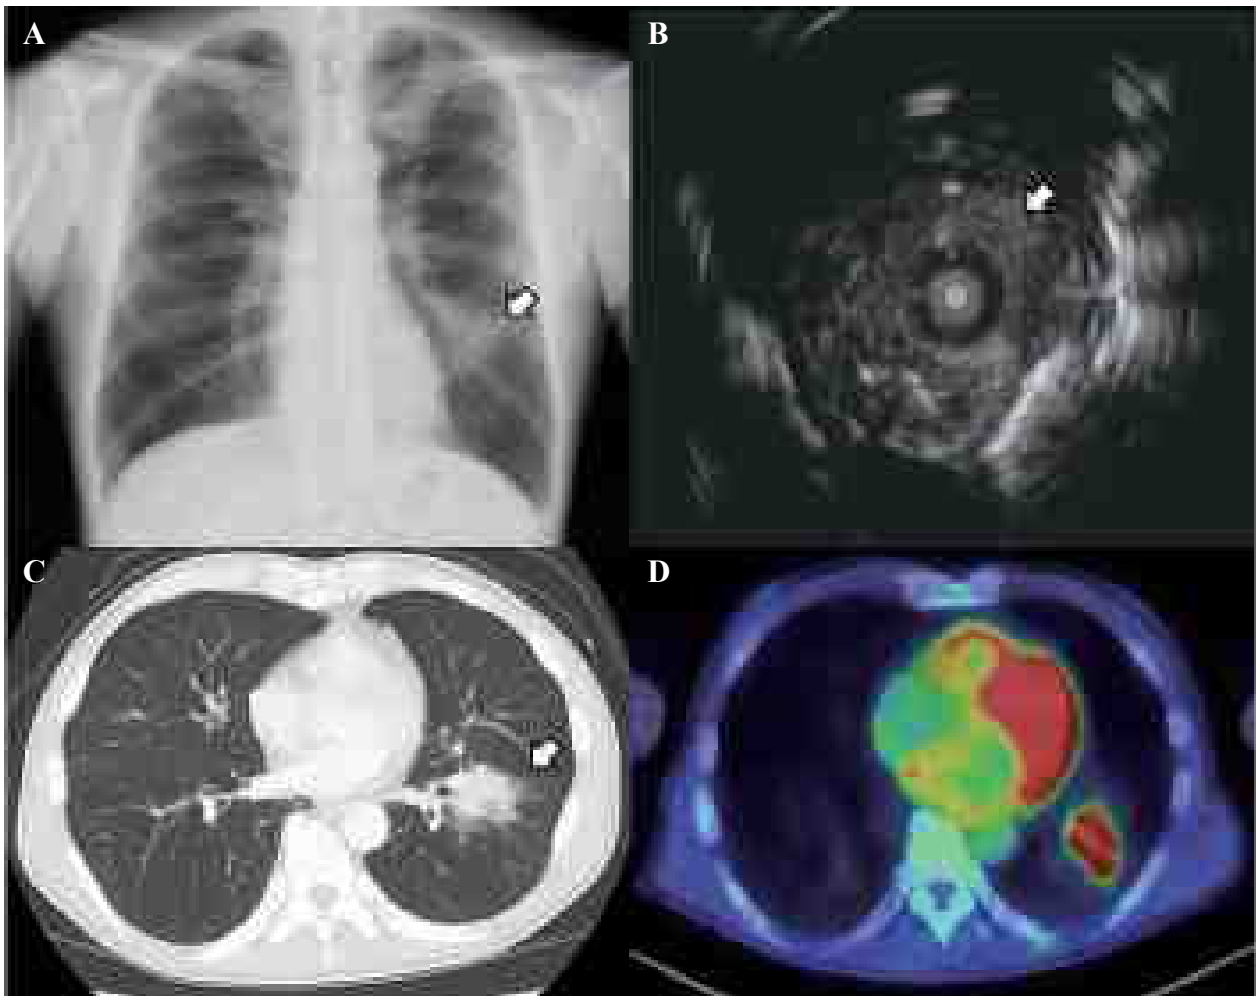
Chest and intra-bronchial image findings on admission. A: Chest X-ray film on admission, showing mass lesions (white arrow) in the left lower lung field. B: Echography through an endobronchial ultrasonography-guided sheath, showing the echo probe was within the lung tumor (white arrow). C: Chest computed tomography on admission, demonstrating lung tumor with spiculations (white arrow) in the left lower lobe. D: Fluorodeoxyglucose positron emission tomography, showing the tumor in the left lobe with a high uptake of fluorodeoxyglucose (red area).
